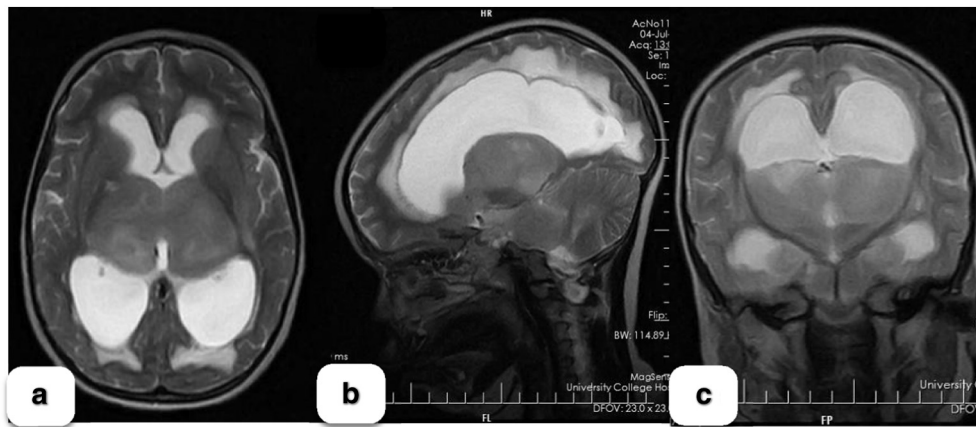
(a–c): T2 weighted brain MRI showing progressive hydrocephalus five months postoperatively. Note the larger size of the lateral ventricles compared to the initial neuroimaging.
